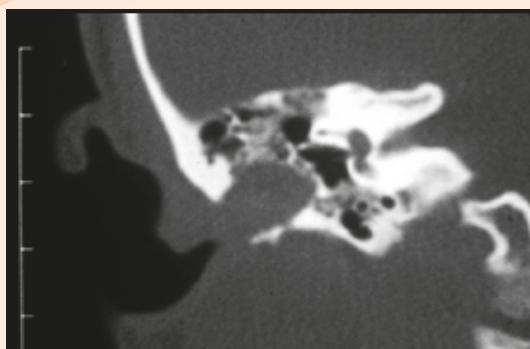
CT scan shows destructive lesion in the external auditory canal, most likely cholesteatoma
